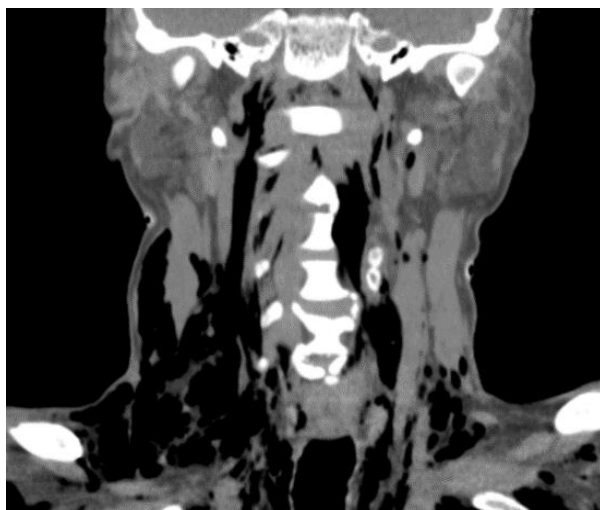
Coronal image of CT on day 19th with bilateral cervical subcutaneous emphysema.
